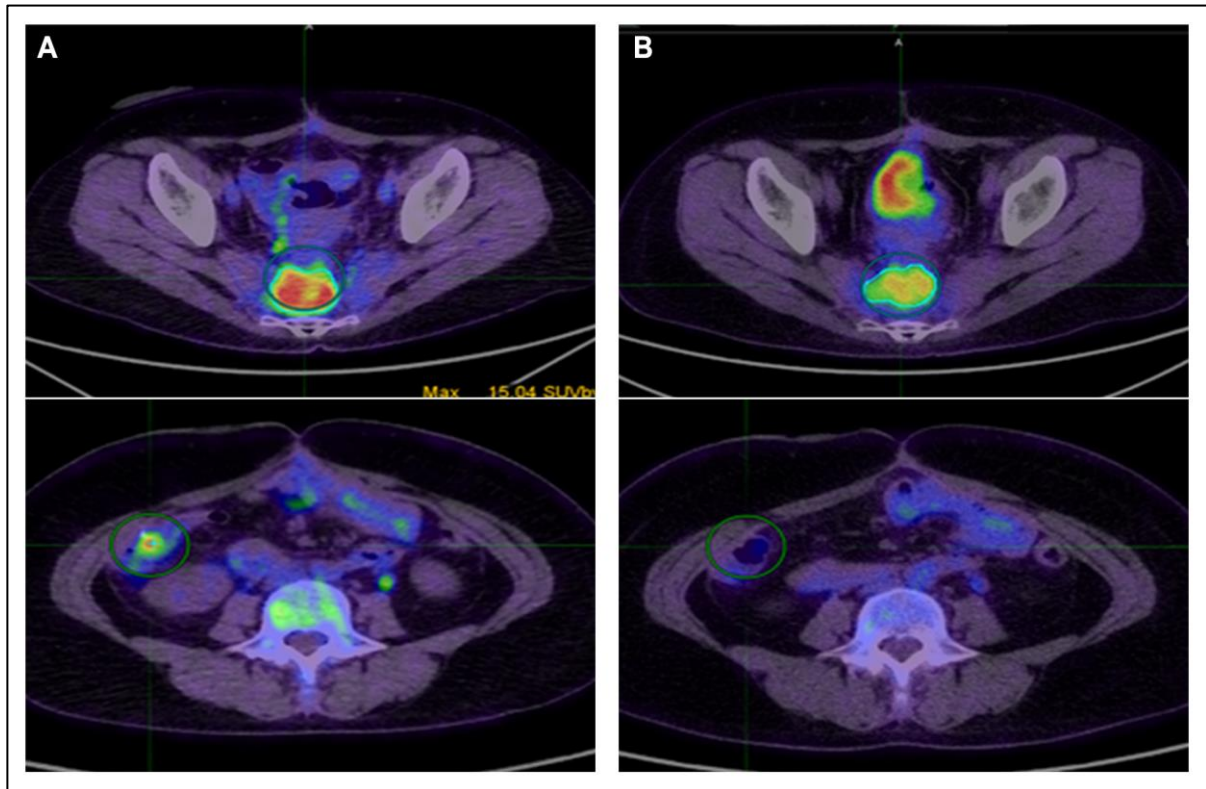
Fig 9.16A demonstrates pre- treatment axial slices demonstrating a FDG PET- avid pre-sacral nodule and a right sided abdominal wall nodule. Fig 9.16B demonstrates complete metabolic response of the abdominal wall nodule, with partial metabolic response in the pre-sacral nodule following treatment with gemcitabine.
